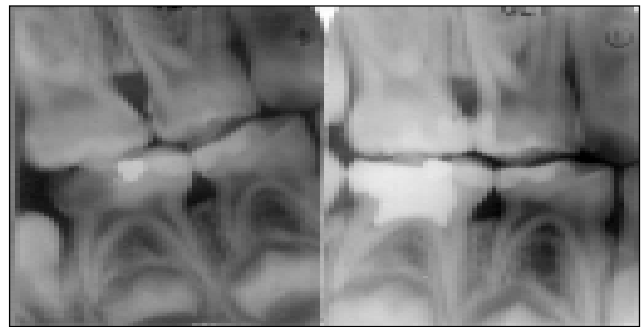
Left: Radiograph before treatment. Right: Complete obliteration of both root canals at nine months after Nd:YAG laser pulpotomy.
